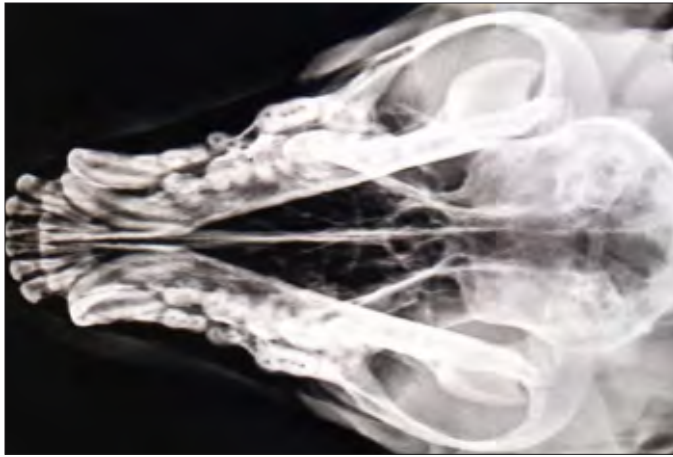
X-ray of skull (ventro-dorsal view) showing no encapsulated mass
